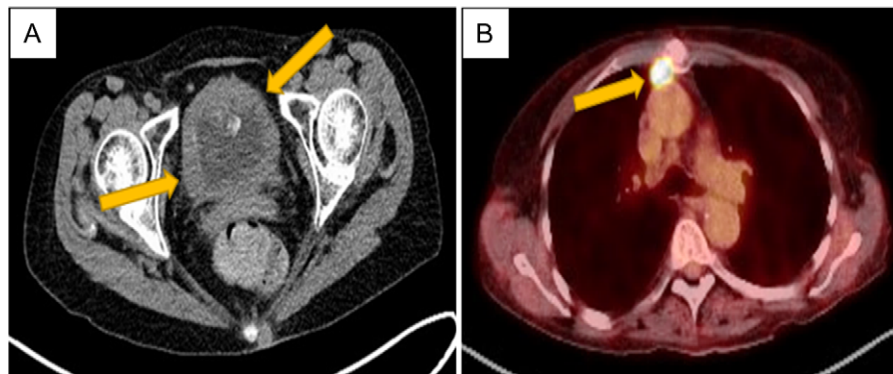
This figure shows the pre-treatment imaging (A) CT scan of the abdomen and pelvis with bladder wall thickening (yellow arrows) and (B) PET scan with pre-vascular avid lymph node (SUV:14) for staging pre-treatment (yellow arrow).
